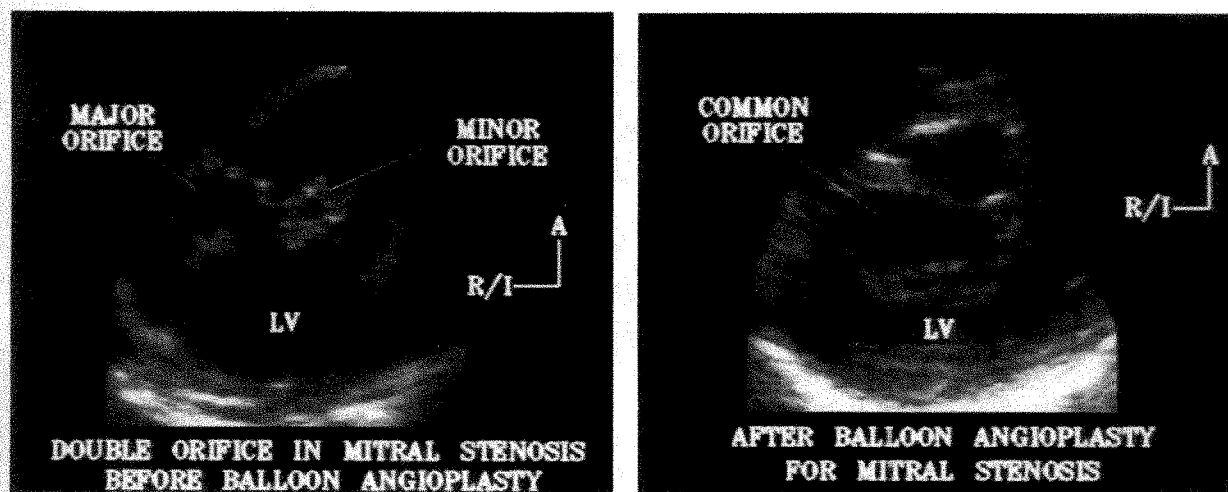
Patient 1. Parasternal short-axis views of left ventricle (LV) and mitral valve. Before dilation (*left*), a bridge of tissue separates a major, medial orifice from a minor, more lateral orifice. A third orifice (not shown) is located more apically. After dilation (*right*), the bridging tissue is torn, resulting in a large common orifice. The movement of the anterior (A) and posterior leaflets is nearly unrestricted. R/I = right/inferior.
